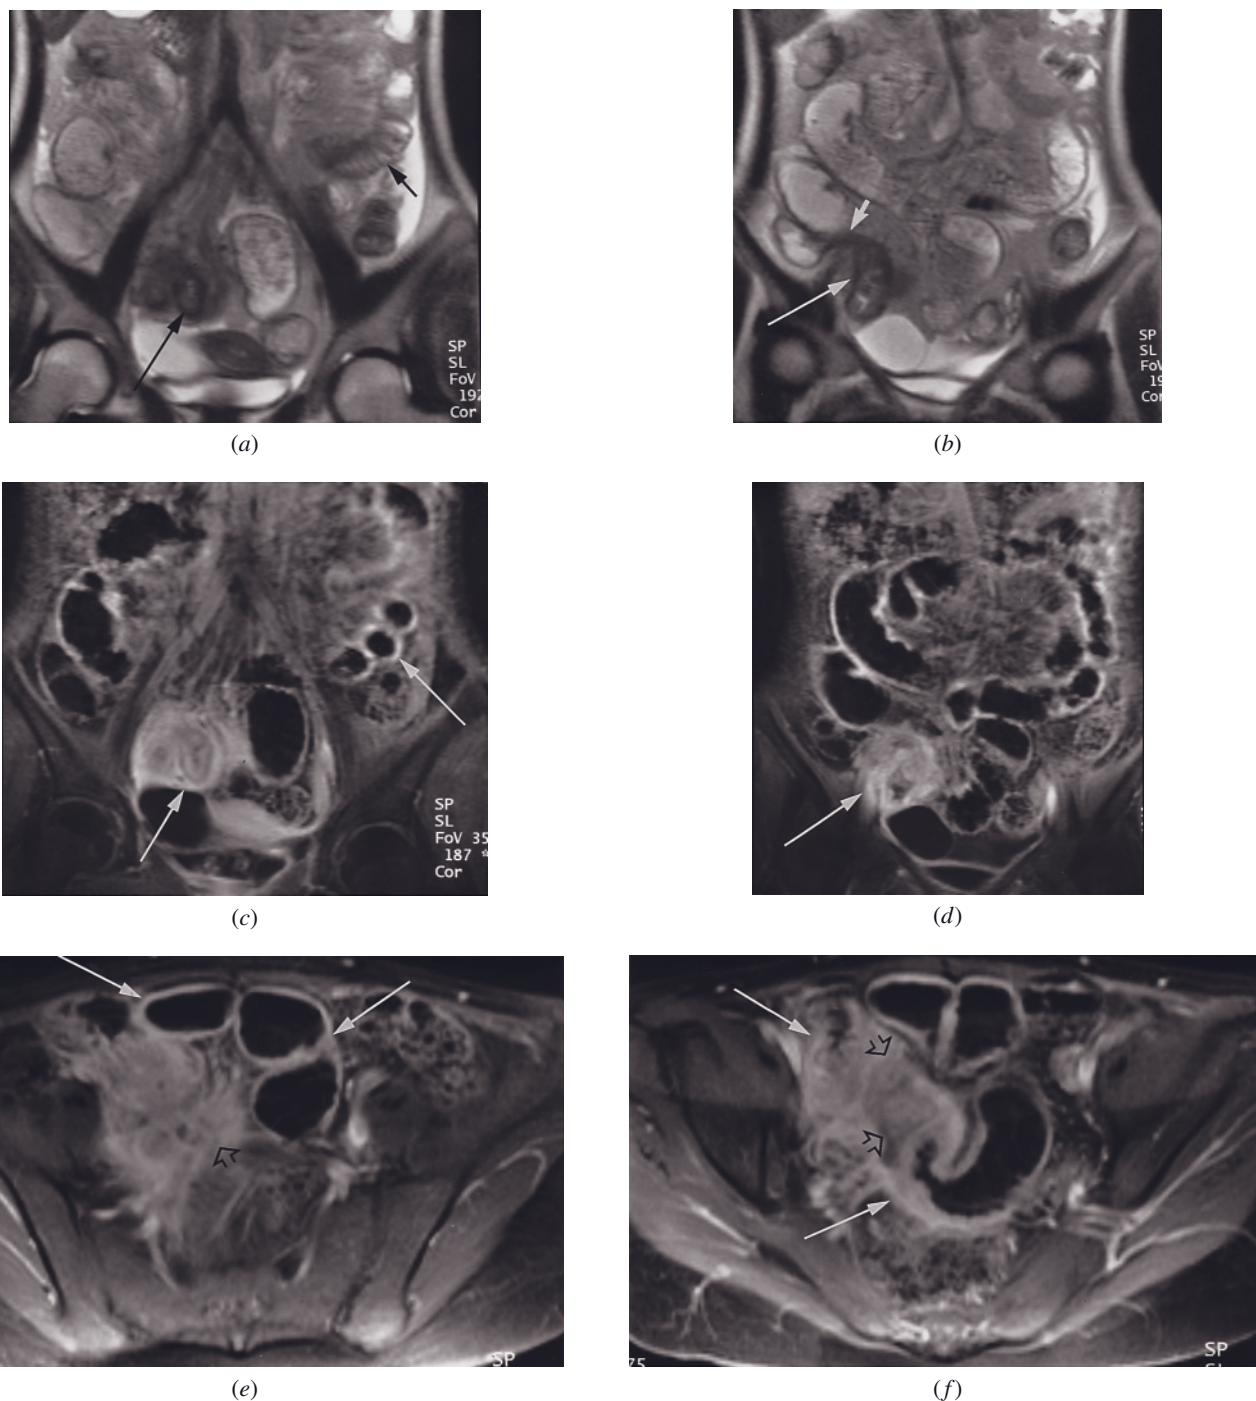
Severe Crohn disease. Coronal SS-ETSE (*a, b*) and coronal (*c, d*) and transverse (*e, f*) 2- to 3-min postgadolinium fat-suppressed SGE images in a patient with severe disease. Coronal T2-weighted images from midabdominal plane (*a*) and 2 cm more anterior (*b*) demonstrate thickened loops of distal small bowel (long arrows, *a, b*). The terminal ileum is well shown at its entry into the cecum (small arrow, *b*). Coronal gadolinium-enhanced fat-suppressed SGE images acquired from similar tomographic sections, respectively, demonstrate substantial enhancement of the thickened loops of bowel and surrounding tissues. An enhancing fistulous tract (arrow, *d*) is apparent close to the ileocecal valve. Transverse gadolinium-enhanced images demonstrate intense enhancement of multiple loops of bowel, including loops with wall thickness of 4 mm (arrows, *e*). On the more inferior tomographic section narrowing of distal ileum is apparent (long arrows, *f*), which accounts for the mild dilation of more proximal loops (arrows, *e*). Inflammatory mesenteric changes are evident (open arrows, *e, f*). Normal-appearing proximal jejunum (small arrow, *a*) is appreciated on the T2-weighted image.
